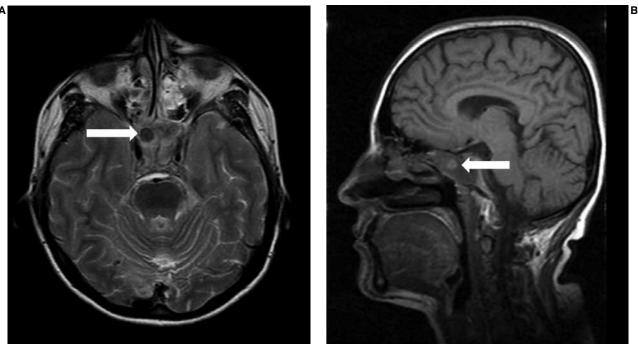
Axial T2-weighted MRI (A) and sagittal T1-weighted MRI (B) show the fungus-ball appearance (arrow) in the right sphenoid sinus.
